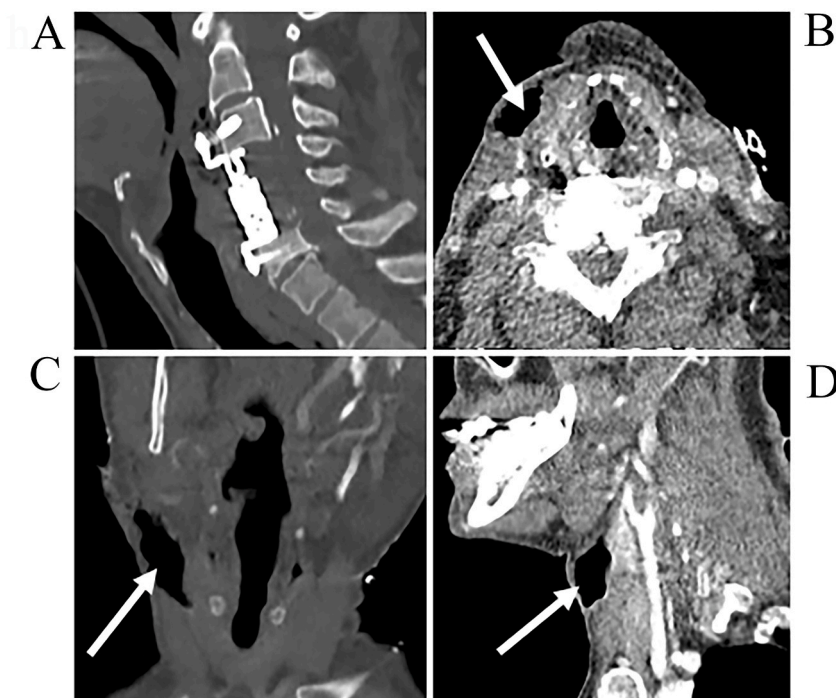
Postoperative computed tomography images showing the implant (A) and subcutaneous air in axial (B), coronal (C), and sagittal (D) views.
